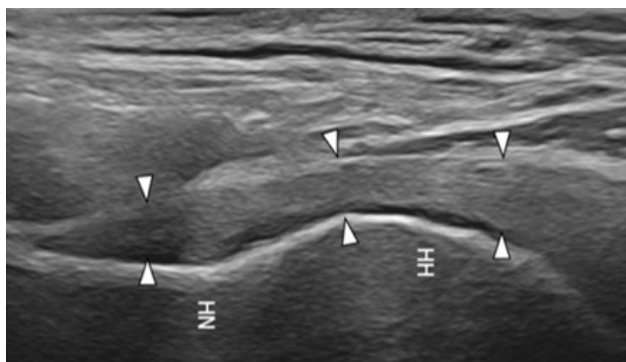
Ultrasonography. Thickened inferior glenohumeral capsule, longitudinal image. Adapted from Picasso et al. [5] with CC-BY.
